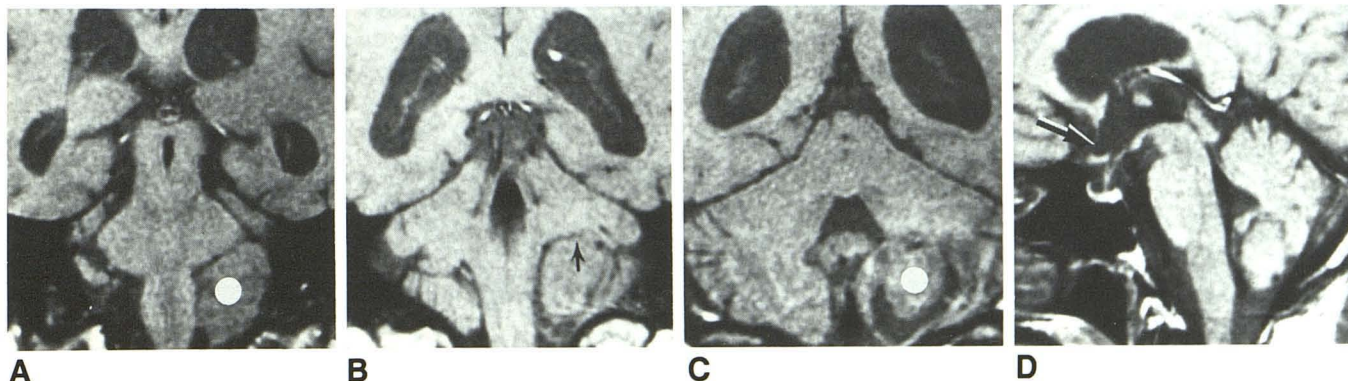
MR images 800/25 (1.5 T) show intra- and extraaxial choroid plexus papilloma involving left lateral recess of fourth ventricle with extension into cistern of cerebellopontine angle (CPA).
